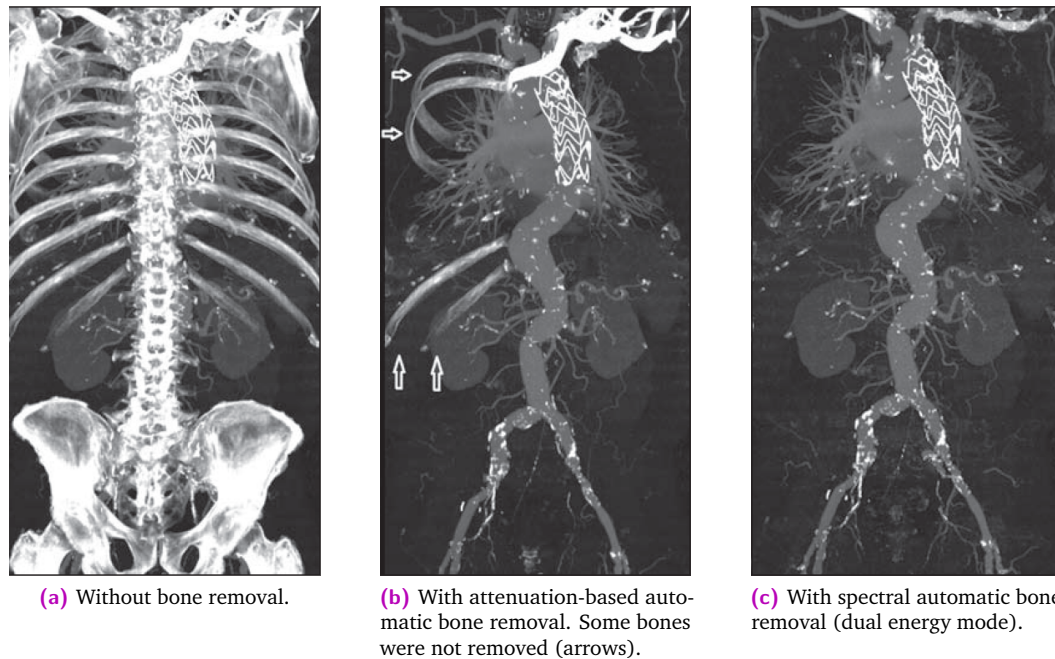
56-year-old man with implanted stent graft in the descending thoracic aorta. Frontal maximum-intensity-projection CT angiograms (from [290]).
